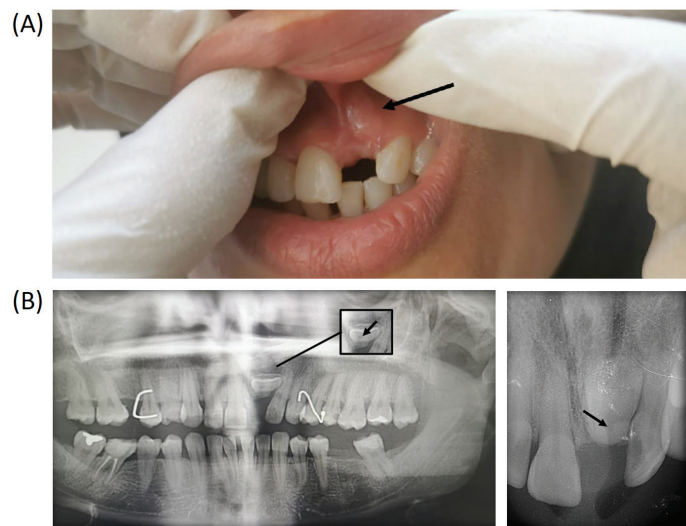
(A) Pre-operative image of the area of concern showing a hard palpable labial bulge. (B) Radiographic examination. The characteristic bull's eye image is observed on the OPG radiograph (Left) and the periapical radiograph (right).
